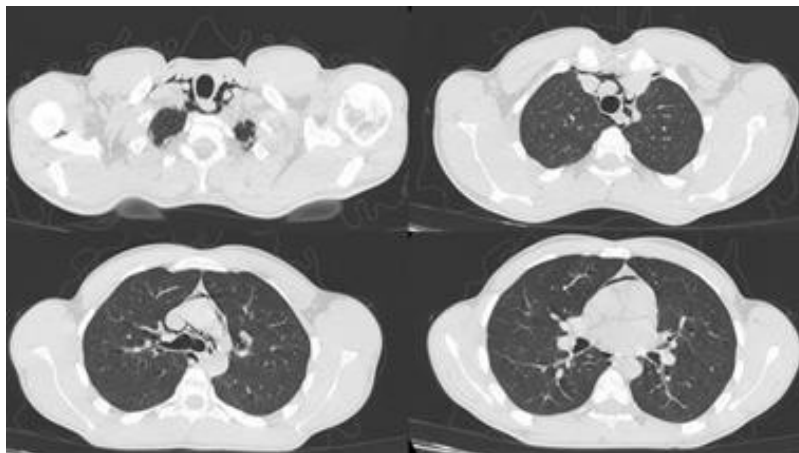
The patient's thoracic computed tomography (CT) images, showing free air within the mediastinum.
